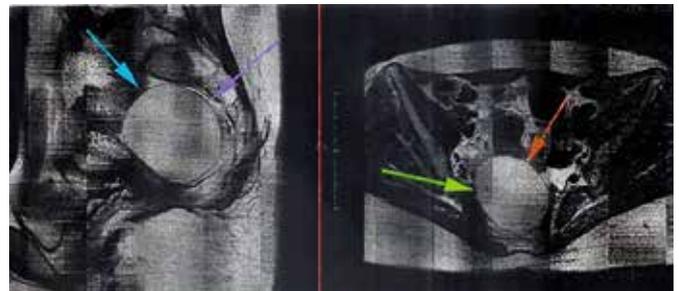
Magnetic resonance imaging shows an image with hyposignal suggestive of a cyst in the right iliac region.
